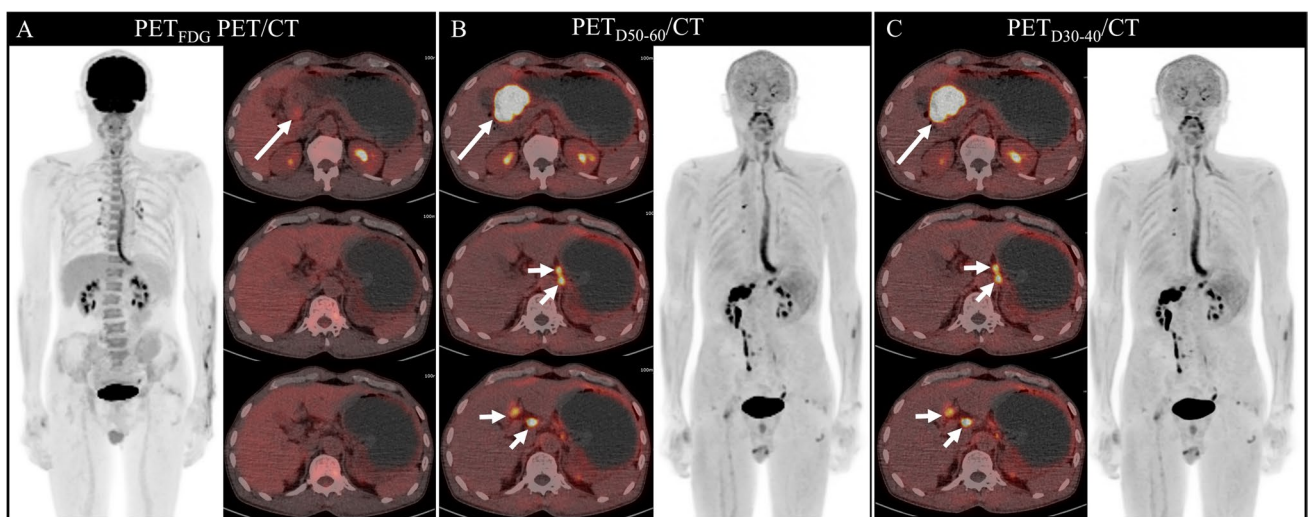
Images obtained in a 66-year-old man with poorly differentiated gastric adenocarcinoma who underwent [¹⁸F]FDG PET/CT (A) and [¹⁸F]FDG/[⁶⁸Ga]Ga-DOTA-FAPI-04 dual-tracer PET/CT (B and C) for initial assessment. Images from [¹⁸F]FDG PET/CT show slight tracer uptake in the primary tumor (long arrow in A) without any positive metastasis. On dual-tracer PET/CT reconstructed 50–60 min
